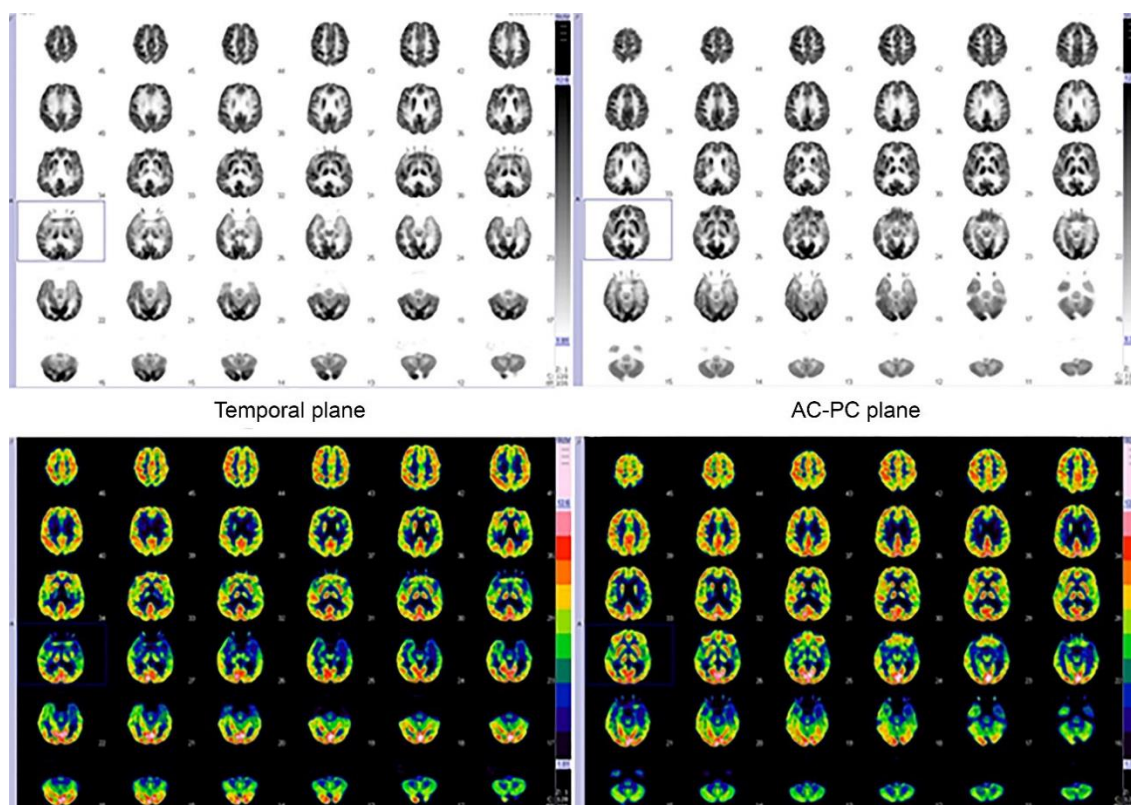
FDG-PET axial image in temporal vs. AC-PC plane in the same patient using grayscale and ten-band color scale
